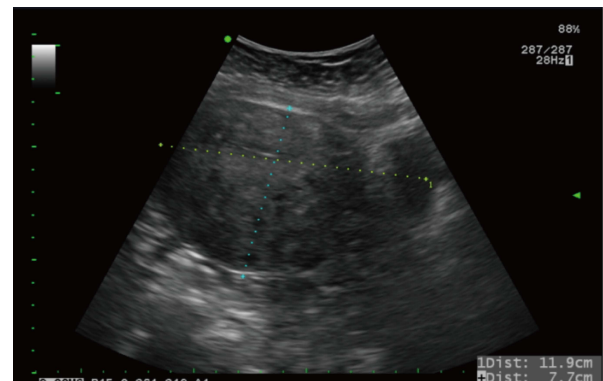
Ultrasound of adenomyosis of uterus. The largest diameter of uterus measured was 11.9 cm.
